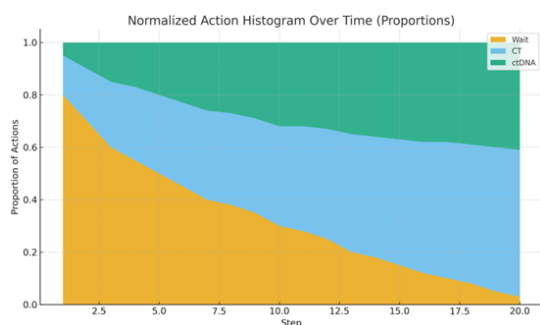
Normalized action histogram showing percentage distribution of Wait/CT/ctDNA across quarterly cycles.
